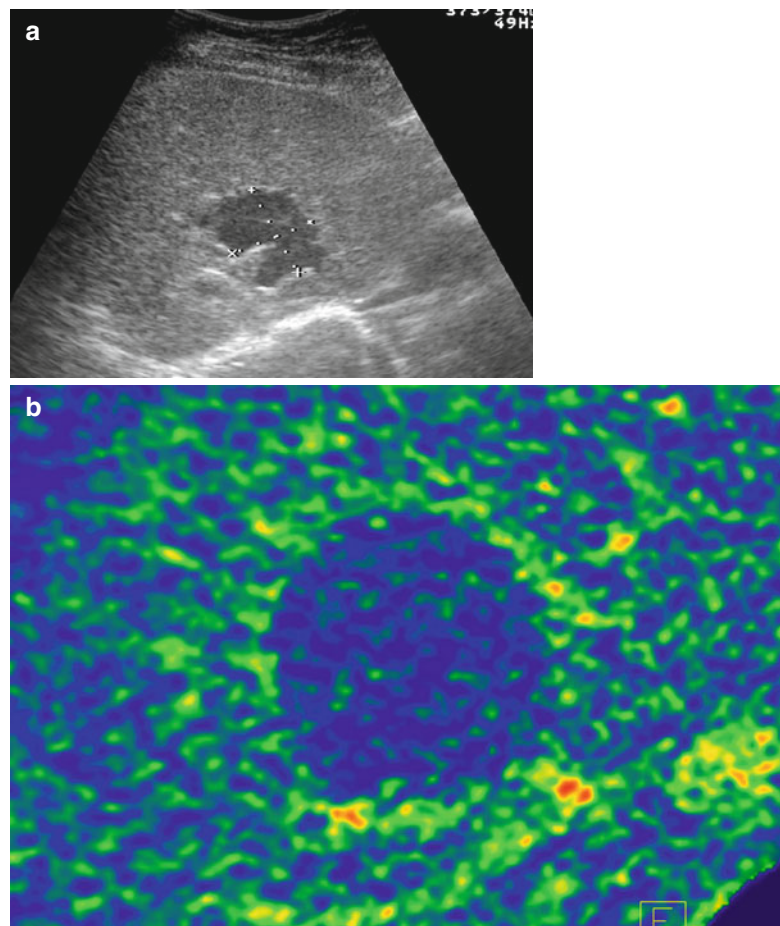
Follow-up of hepatic cysts after sclerotherapy. Residual small cyst with thick, irregular walls at US (a). Slight enhancement of cyst wall in dual-energy CT scan, volume reduction was 98 % (b)
